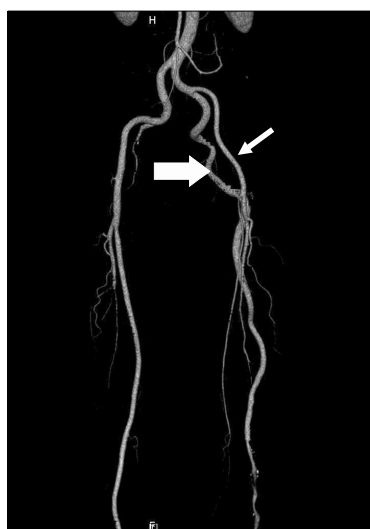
Preoperative computed tomography angiogram (1st operation). The presence of complete persistent sciatic artery (large arrow) with incompletely developed superficial femoral artery (small arrow) was noted. It also presented the complete obstruction of distal popliteal artery by thrombus and tapering-off of the arterial flow distal to popliteal artery. Persistent sciatic artery originated from internal iliac artery shows relatively preserved patency without any aneurismal change.
